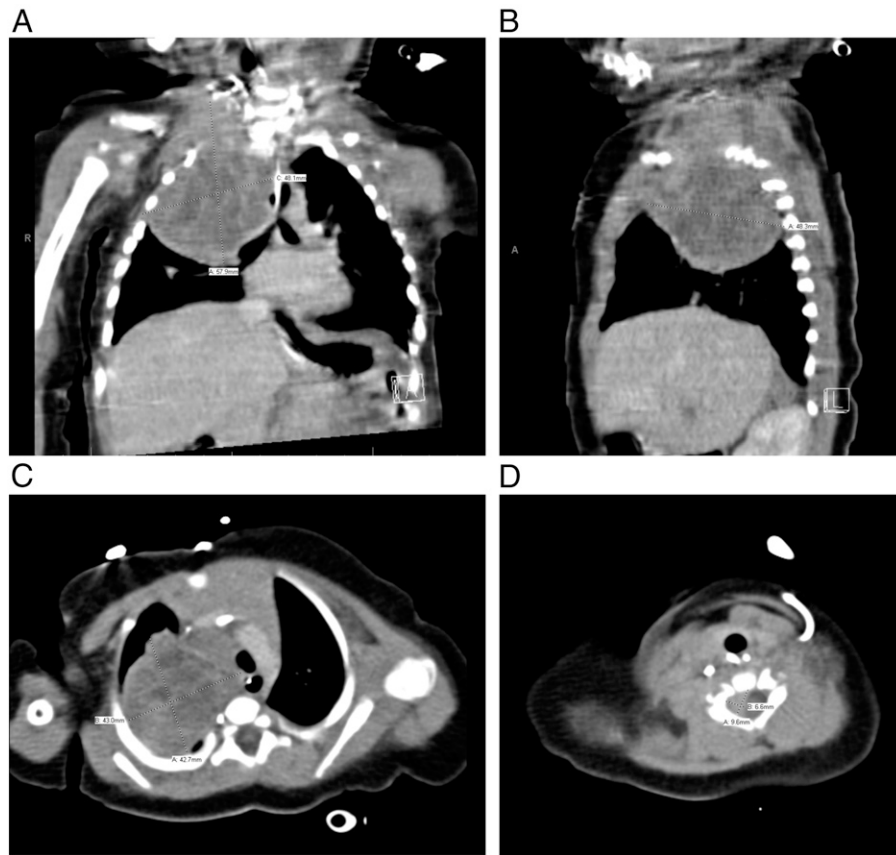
A. Coronal CT showing large heterogenous mass occupying the right upper thorax and extending into the neck. B. Sagittal CT showing the anterior-posterior dimension of the mass. C. Axial CT showing deviation of the mediastinal structures. D. Axial CT showing extension of the mass into the spinal column with deviation of the spinal cord.
